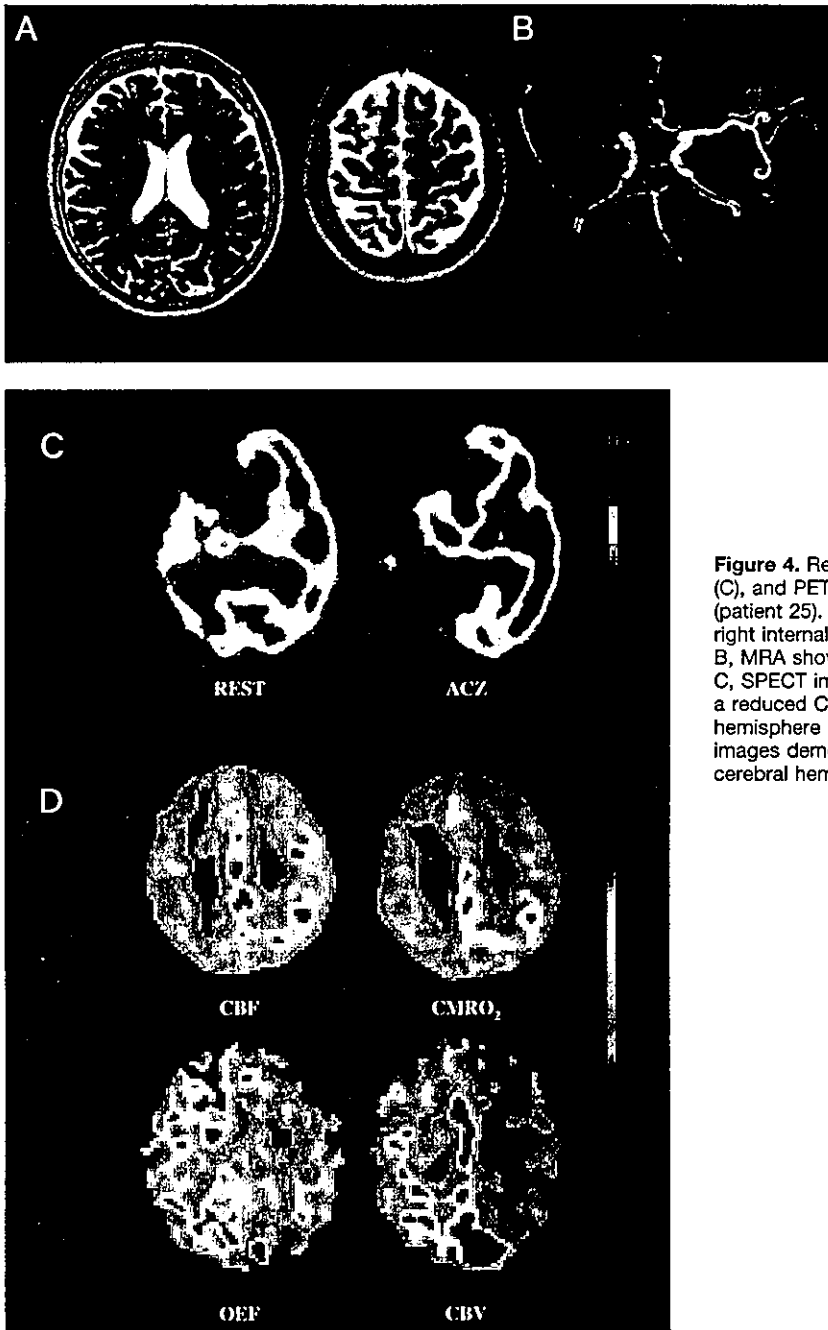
Representative MRI (A), MRA (B), SPECT images (C), and PET images (D) in a patient with misery perfusion (patient 25). This patient is a 69-year-old woman with a right internal carotid occlusion. A, MRI shows no infarction. B, MRA shows occlusion of right internal carotid occlusion. C, SPECT images demonstrate a reduced CBF at rest and a reduced CVR after ACZ challenge in the right cerebral hemisphere (CBF index=0.62, CVR=-0.07). D, PET images demonstrate an elevated OEF and CBV in the right cerebral hemisphere (OEF=61%, CBV=5.8%).
